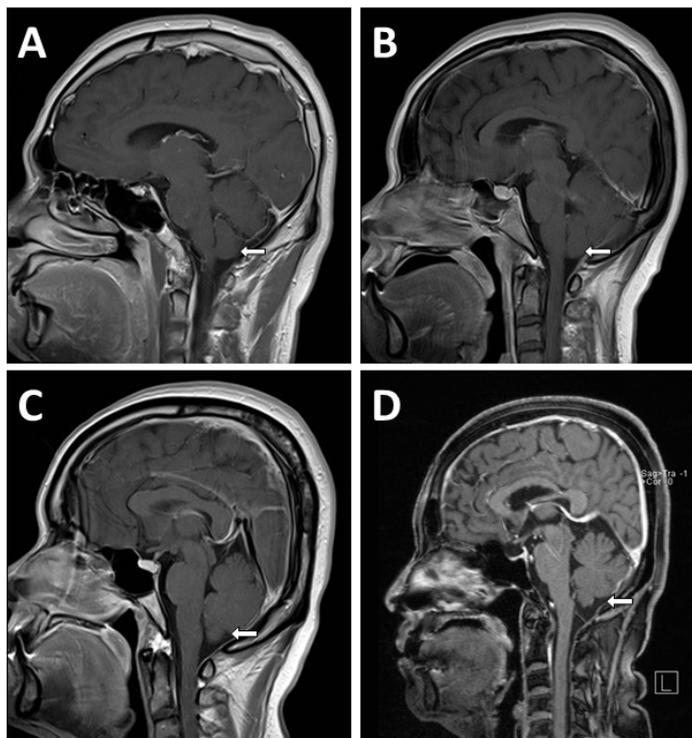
Sagittal view of the gadolinium-enhanced T1-weighted brain MRI of the four patients, showing sagging of brain. (arrows) A. Patient 1; B. Patient 2; C. Patient 3; D. Patient 4.
